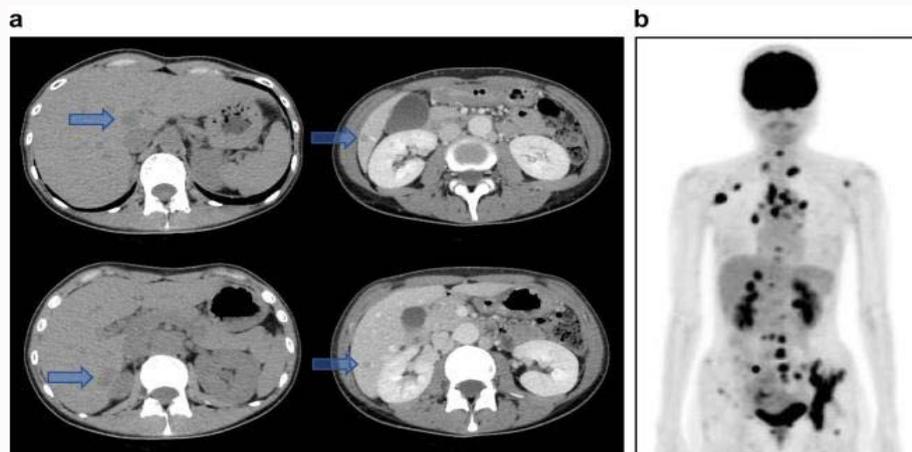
Computed tomography (CT) image showing multiple liver metastases (arrow, a); Fluoro-D-Glucose Positron Emission Tomography (FDG-PET)/CT showing multiple lymph nodes and bone metastasis (b).
